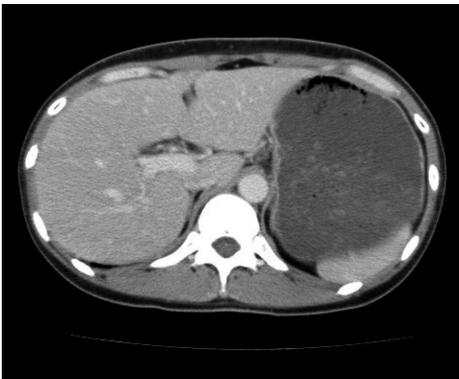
Abdominal contrast enhanced computed tomography 24 h after endoscopic submucosal dissection. Free air is not recognized.
